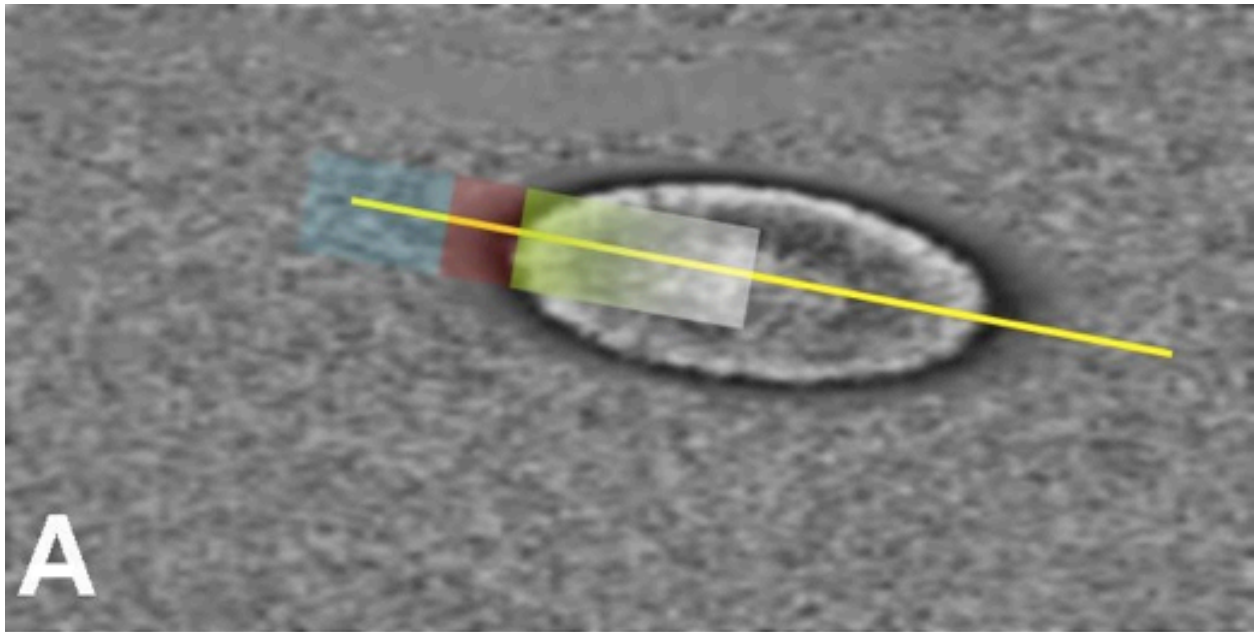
Doppler shift noise versus signal
